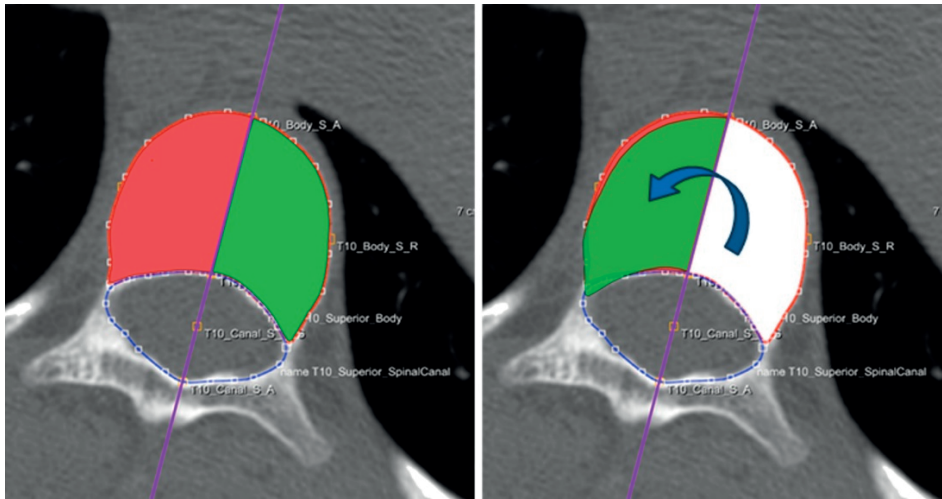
Computed tomographic images showing the true transverse reconstructions of a vertebra. After manual segmentation of the vertebral body and spinal canal the software flipped the right side of the endplate across the longitudinal vertebral axis. The Dice similarity coefficient was used to calculate the percentage of overlap between the left (in *green*) and right (in *red*) side of the vertebral body.
